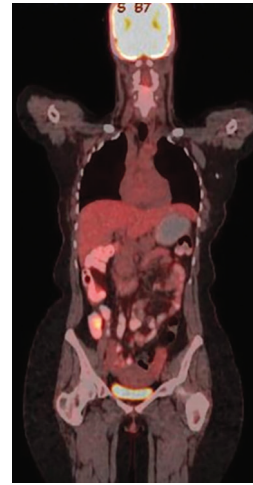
Whole body F18-FDG PET/CT showing circumferential wall thickening of the ascending colon
